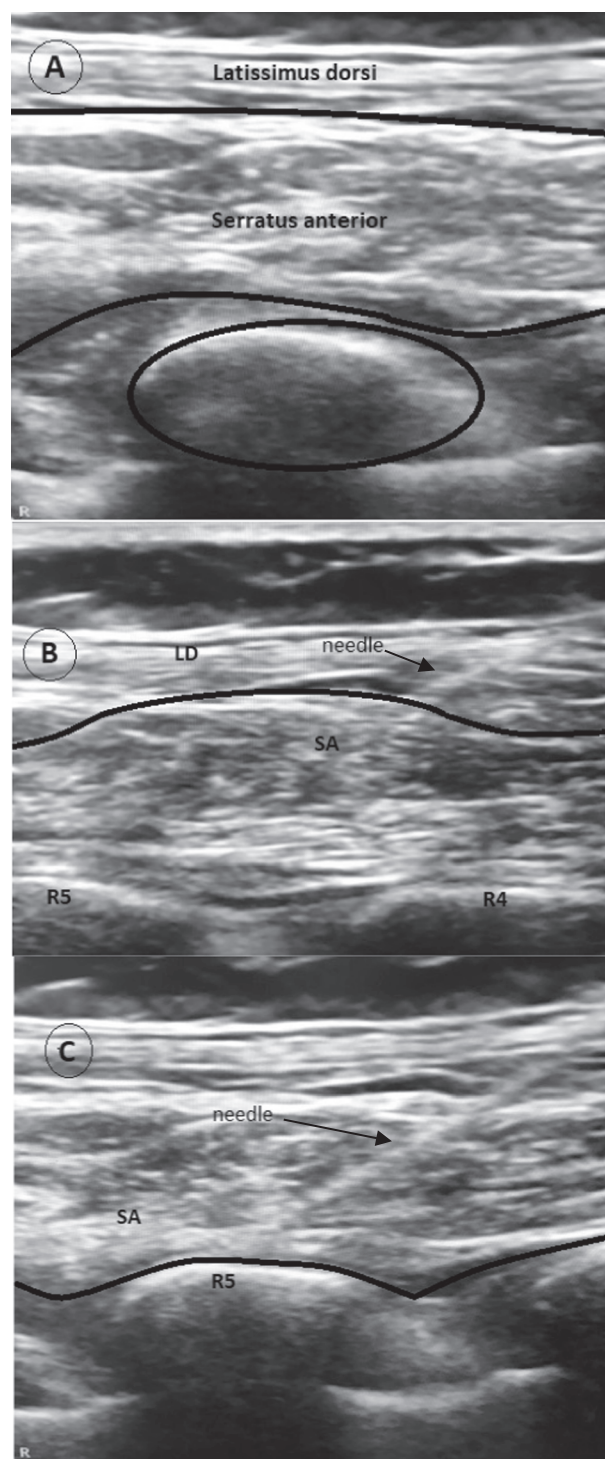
Ultrasound image in a midaxillary line of the latissimus dorsi and the serratus anterior panel A: ultrasound image of the fifth rib, serratus anterior muscle and latissimus dorsi muscle in a midaxillary line. panel B: superficial serratus anterior block. panel C: deep serratus anterior block. SA: Serratus Anterior. LD: Latissimus Dorsi. R4: fourth Rib. R5: fifth rib.
